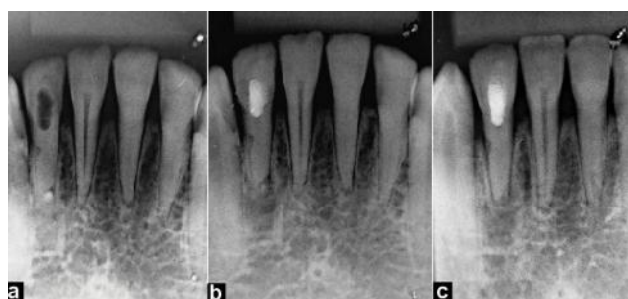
Follow-up Radiographic Images (a) Immediately After Surgery, (b) After 2 Months, (c) After 6 Months.
